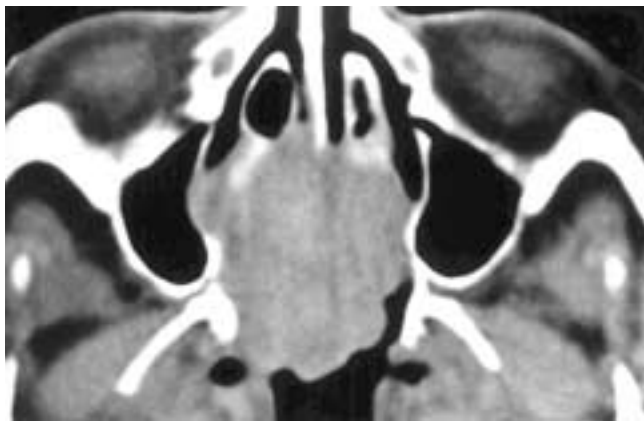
Axial CT scan shows a bulky, lobulated posterior nasal fossa mass centered on the nasal septum. There is minimal thinning of the medial right antral wall. The dominant finding is expansion of the nasal vault. This patient had a large cell lymphoma.
